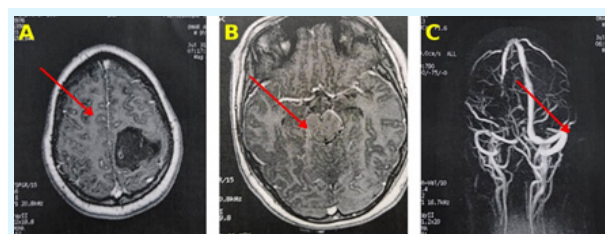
Brain MRI and MR angiography findings in infective endocarditis with suspected mycotic aneurysm.
